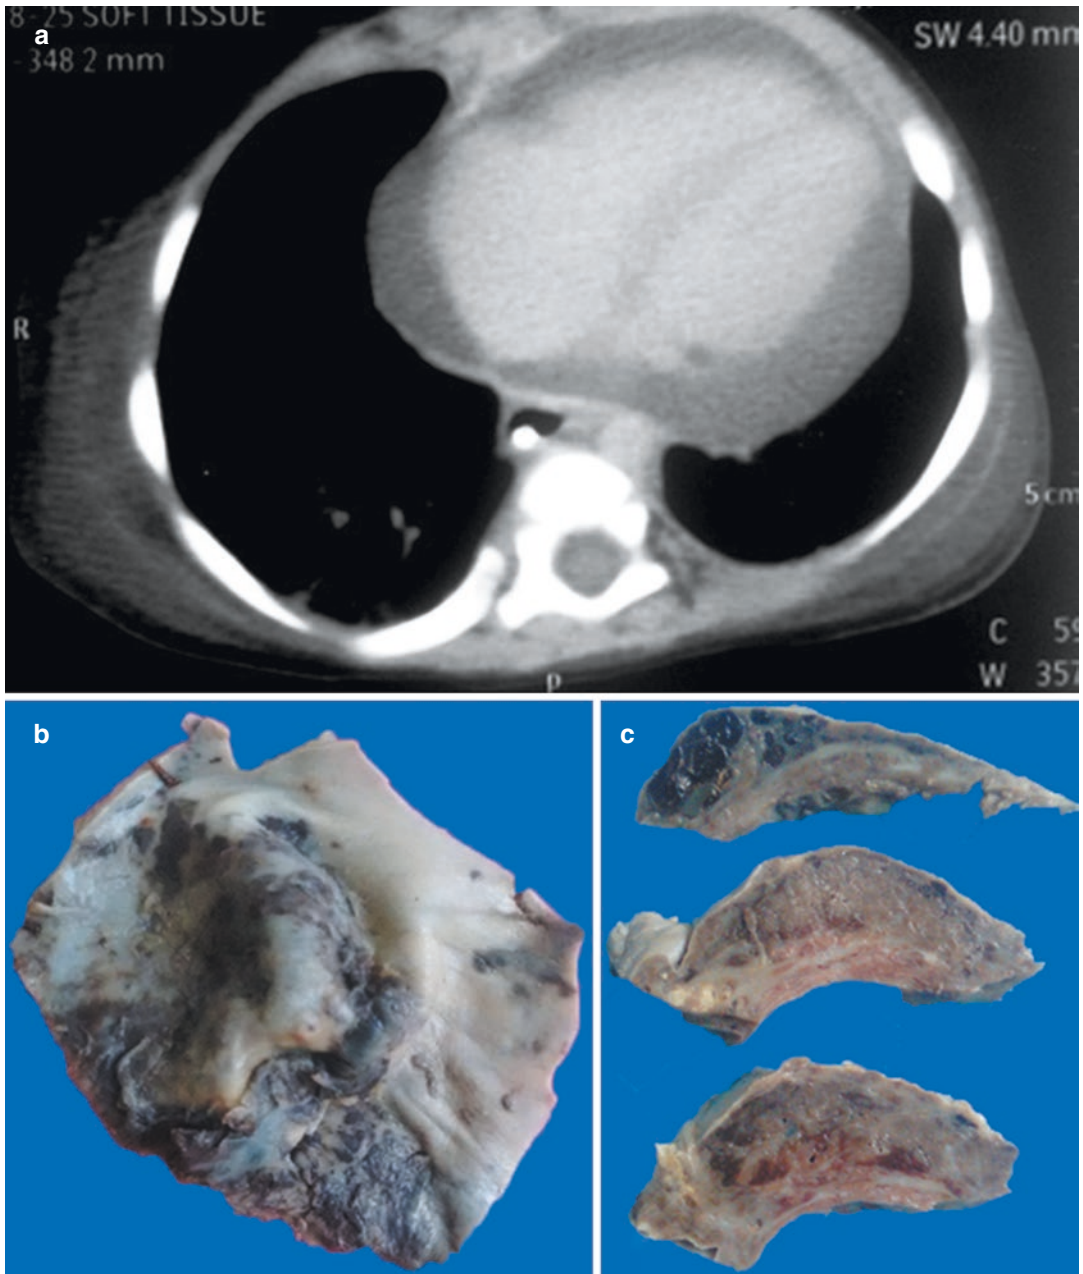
(a) Moderate pericardial effusion on the CT scan; (b) Focal hemorrhagic appearance of inner aspect of parietal pericardium; (c) Pericardial thickening due to spongy hemorrhagic to pale red tissues
